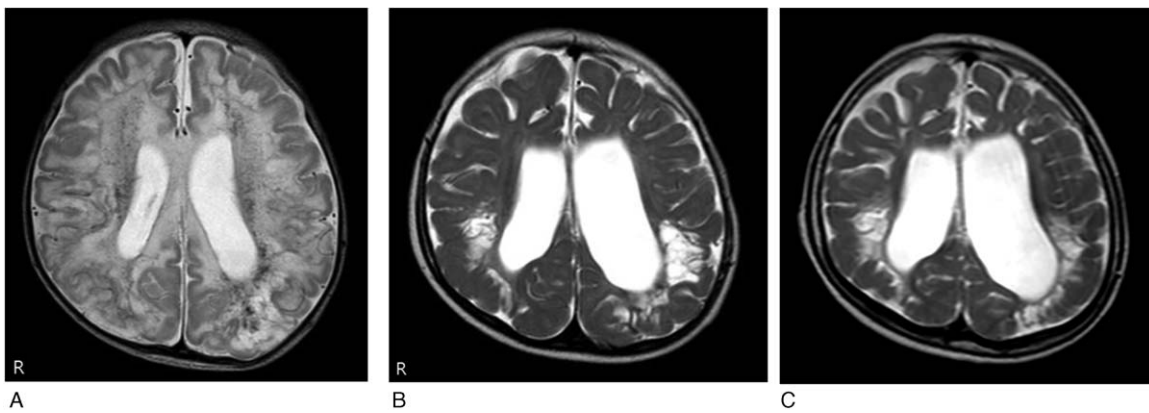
Initial Brain MRI showed severe, diffuse microhemorrhages in the periventricular region, centrum semiovale, precentral and postcentral gyri, and macrohemorrhages in the bilateral parietal and occipital lobes (A), which led to diffuse encephalomalacia involving whole white matter in second (B) and third (C) brain MRIs, suggesting long-term sequelae of hypoxic WMI.
